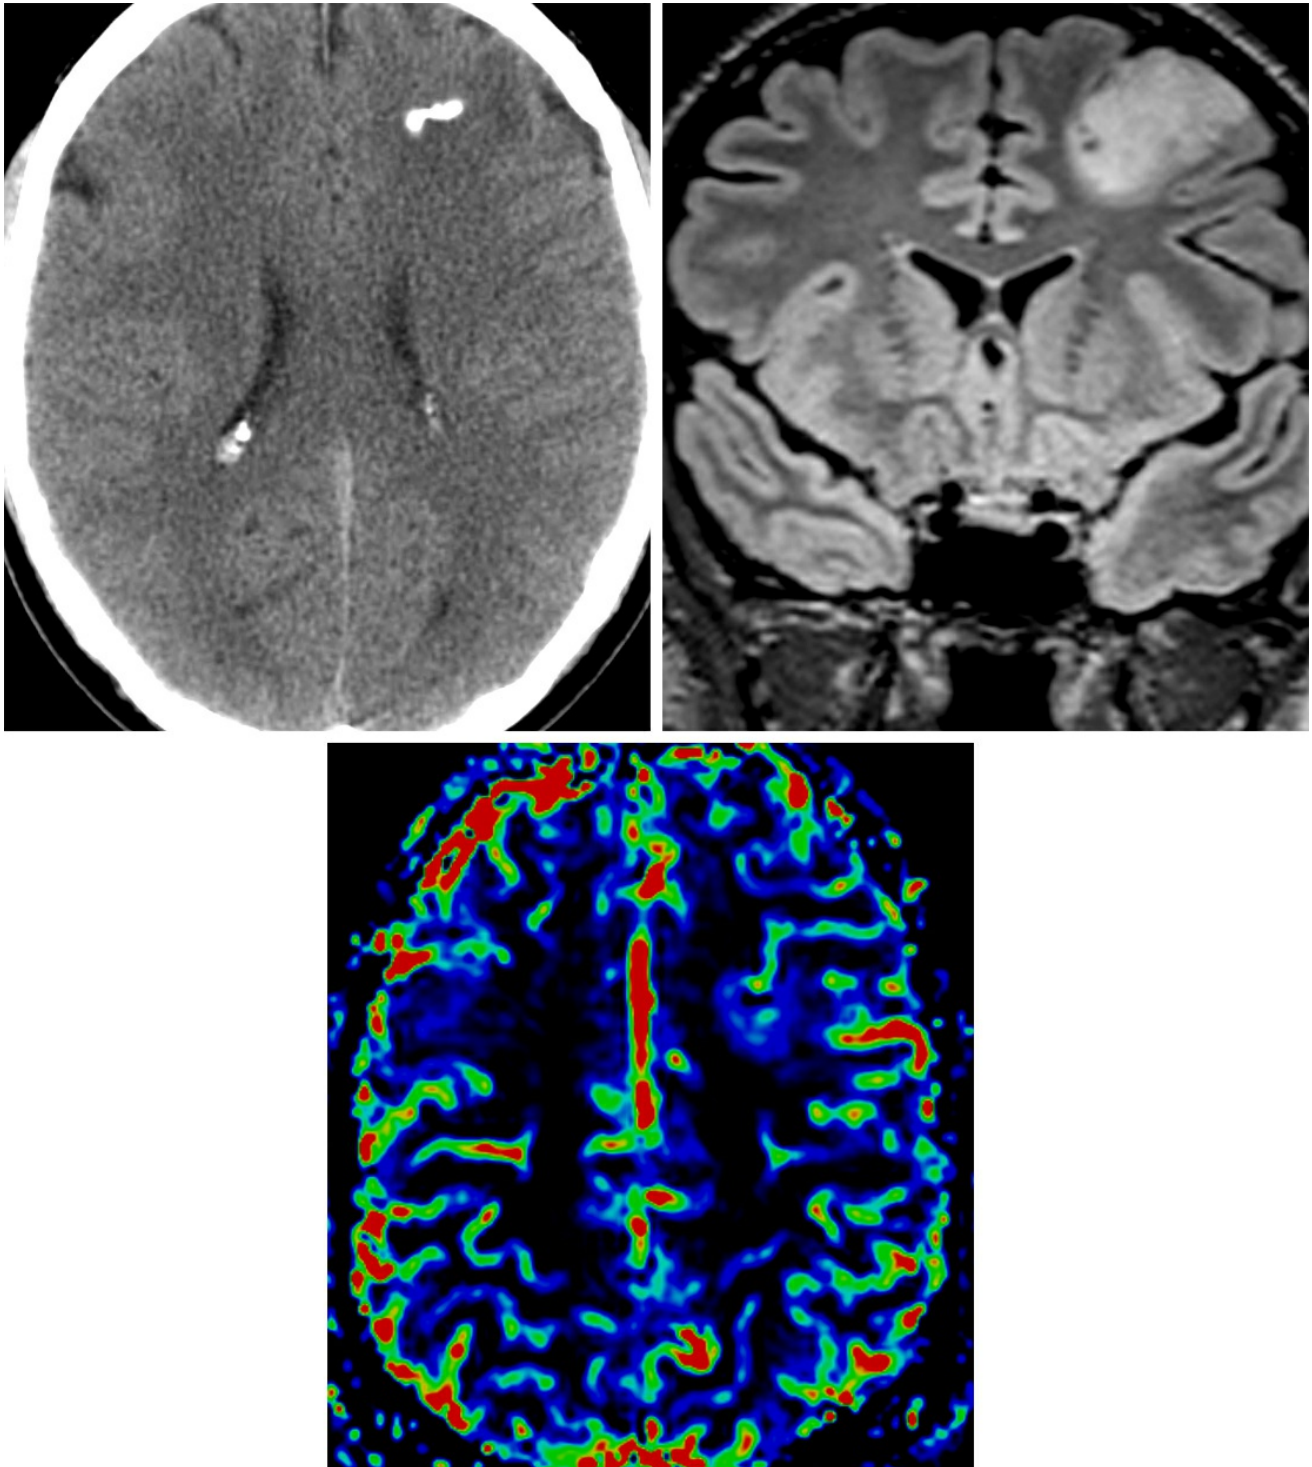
(Top Left) This oligodendroglioma has internal coarse calcification on CT imaging that is very typical of this type of tumor. (Top Right) A coronal FLAIR image demonstrates typical fairly circumscribed
